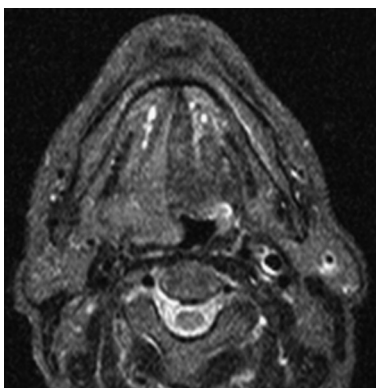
Magnetic resonance imaging spin echo T2 fat-suppressed sequences in the axial plane.
